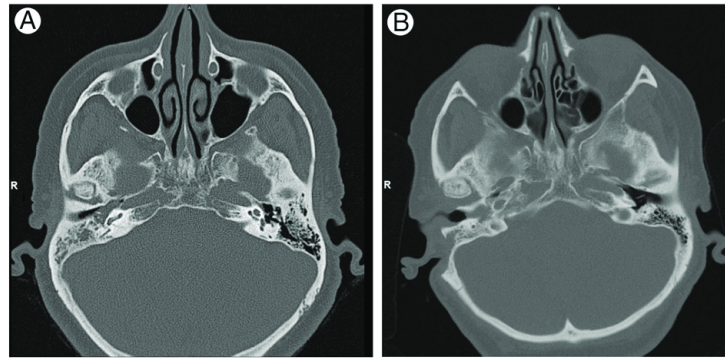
A, CT scan from 2009. A complete obliteration of right mastoid air cells and cavum tympani with a dense content. No destruction or reactive sclerosis of the surrounding bone. B, CT scan from 2013. The presence of some dense content in residual mastoid air cells and cavum tympani can be seen. No destruction of the surrounding bone.
